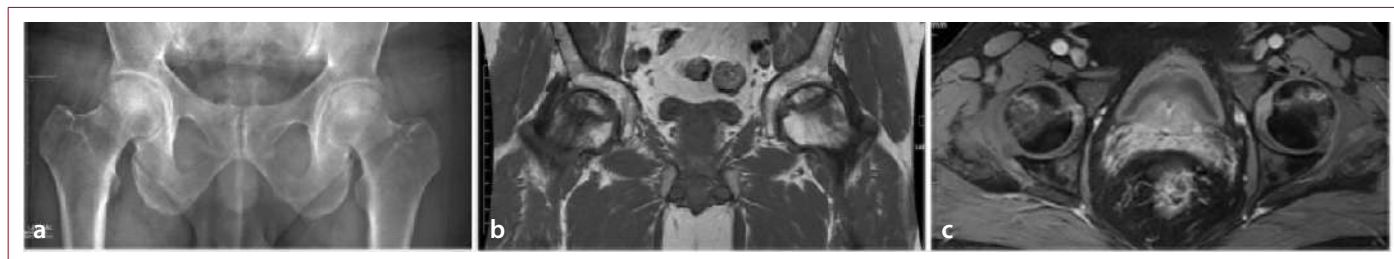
X-ray (a) and MRI (b,c) images of a 36-year-old male patient presenting with progressive worsening bilateral hip pain, without any underlying cause. (a) X-ray failed to demonstrate any pathological signs. (b) T1-weighted MRI image slice, showing well-defined lesions in the superior aspect of the femoral heads. (c) Bilateral bone marrow edema around the lesion in T2-weighted MRI image slice.
